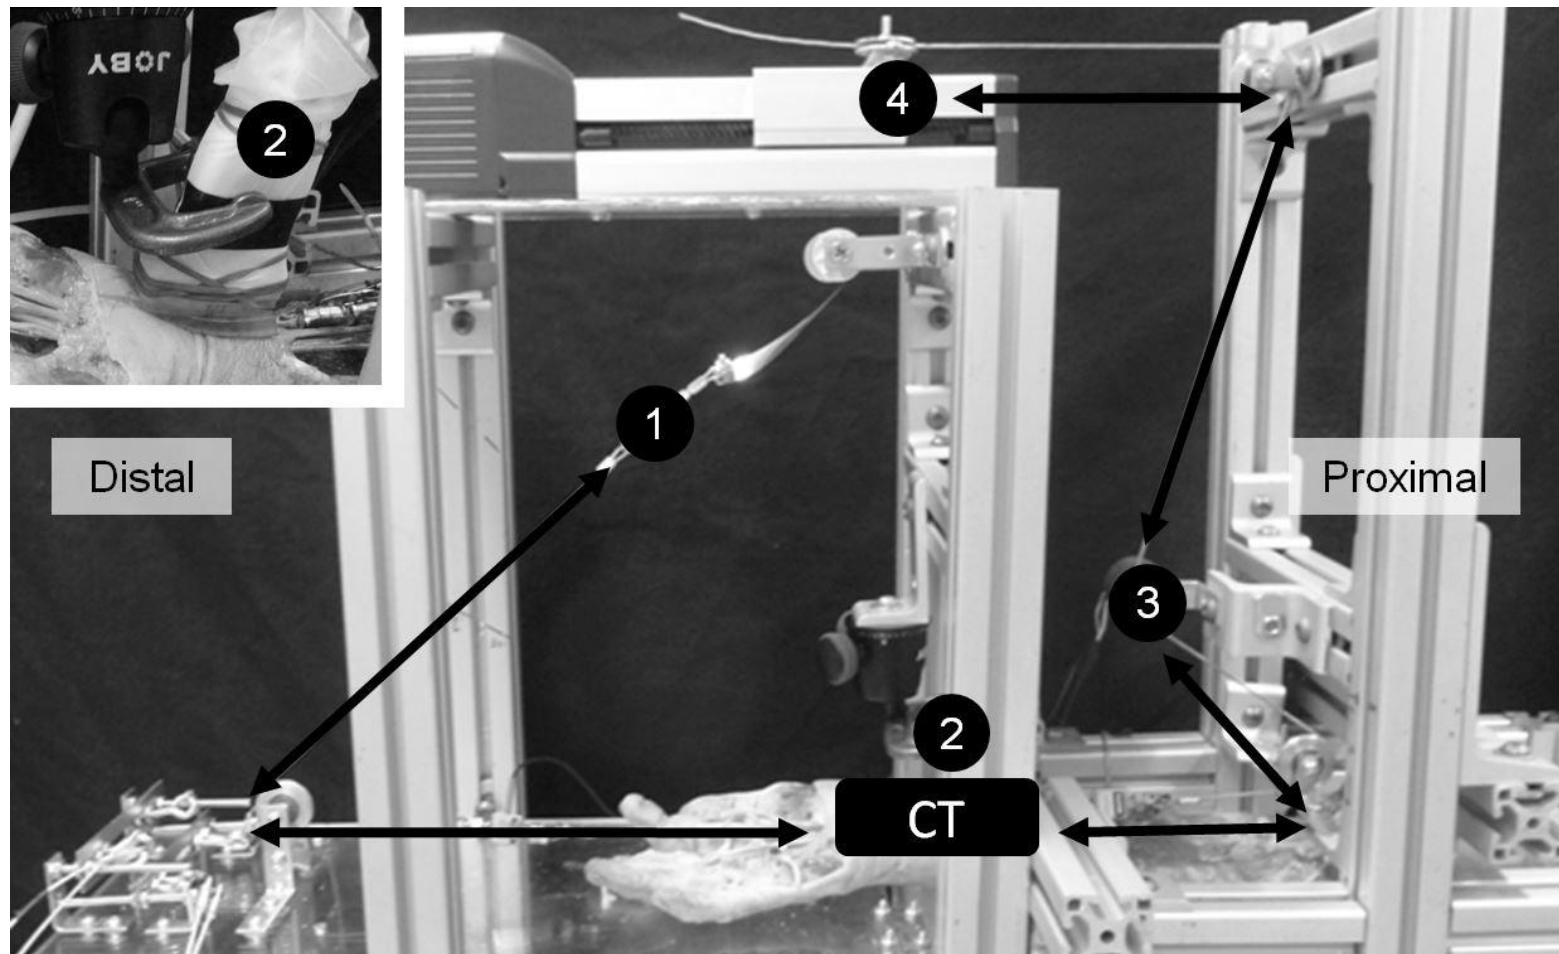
A cadaver forearm in the testing apparatus. The tendon line moves only the middle FDS tendon in the proximal-distal directions as indicated by the arrows. The tendon line consists of a (1) constant force spring, (2) ultrasound probe, (3) rotary potentiometer, and (4) mechanical actuator. (Above left) Close up of the probe positioned above the carpal tunnel (CT) using a gel wedge as a coupling medium.
